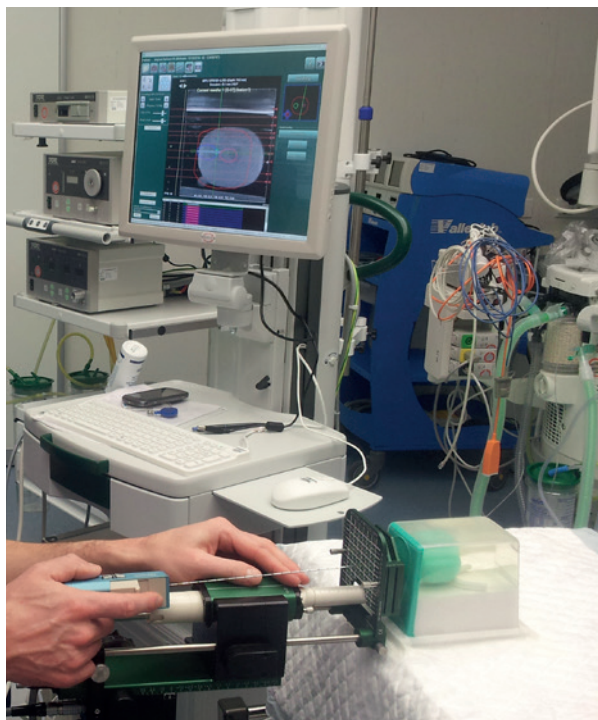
MRI-TRUS fusion biopsy procedure using the BiopSee device.
